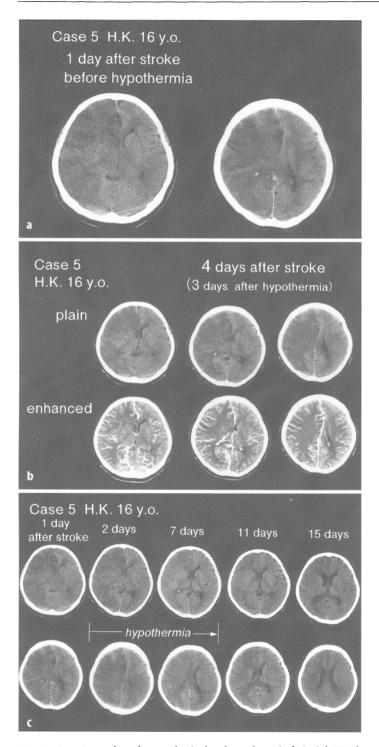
a Case 5 one day after stroke, before hypothermia. b Serial CT of case 5. c Enhancement CT of case 5 4 days after stroke
